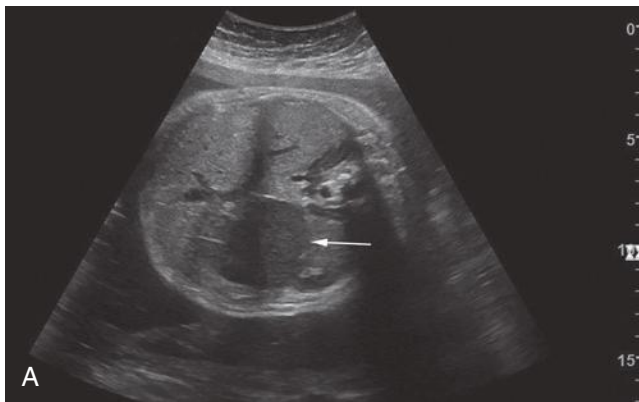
Abdominal mass. A, Sonogram obtained at 34 weeks' gestation reveals a moderately echogenic mass (*arrow*) at the left upper quadrant of the fetal abdomen. B, The mass (M) demonstrates echogenicity similar to that of adjacent bowel (Bo) and appears to be "connected to" and inseparable from the bowel. C, Color Doppler ultrasound imaging reveals blood flow within the mass (*arrows*), making it unlikely that this represents bowel. In addition, careful evaluation of part A reveals that the mass abuts the portal vein, thus suggesting that the lesion is of hepatic origin. Postnatal evaluation revealed infantile hepatic hemangioma.
